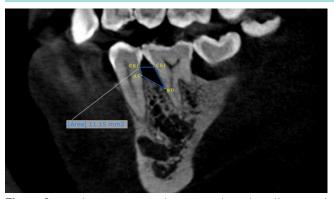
cone beam computed tomography at baseline – sagittal view -area of the defect
